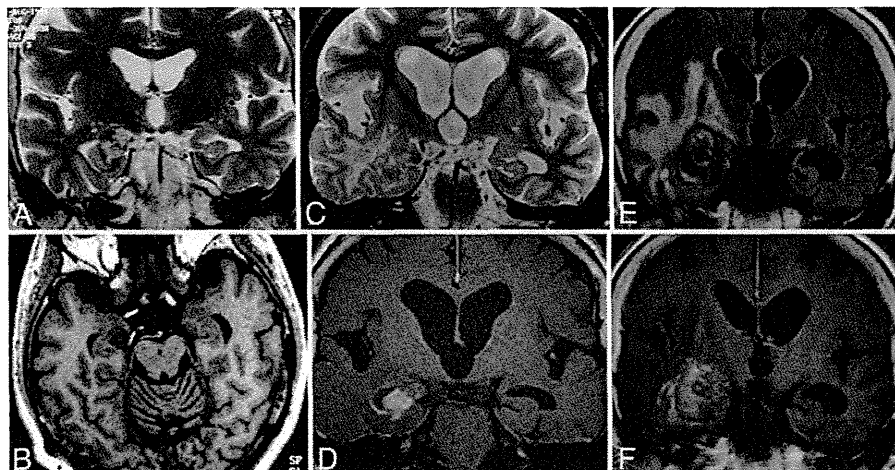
Case 4. Magnetic resonance images. Coronal T2-weighted (A) and axial T1-weighted (B) images obtained before GKS showing a cavernous malformation in the right mesial temporal lobe. Coronal T2-weighted (C) and Gd-enhanced (D) images obtained 8 years after GKS showing hydrocephalus, a small area of radiation necrosis, and edema in the temporal lobe. Coronal FLAIR (E) and Gd-enhanced (F) images obtained 10 years after GKS showing improvement in hydrocephalus but deterioration of radiation necrosis and edema.
